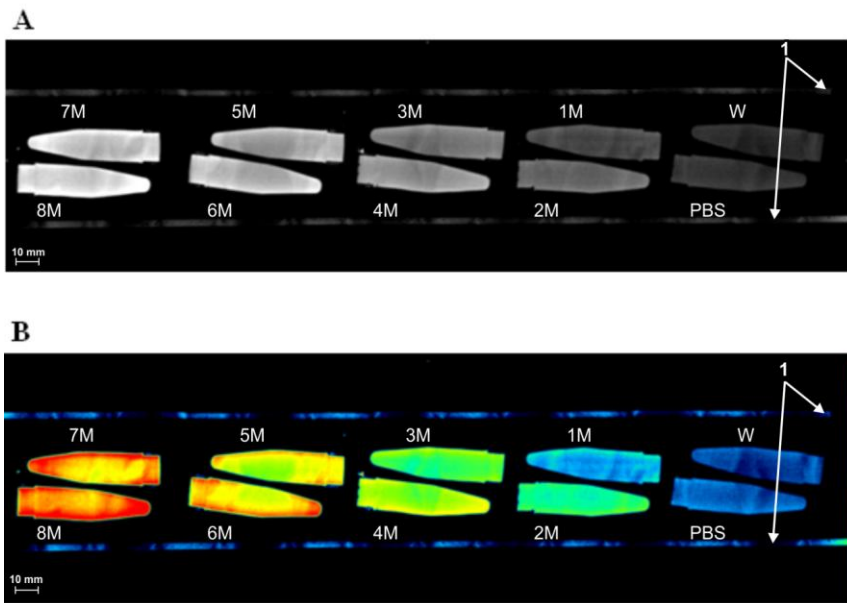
CT image of 10 Eppendorf tubes with different solutions of Me₂SO in PBS, at 20 °C. Top image (A) uses the gray scale and bottom image (B) the cold scale. In both scales, bottom row, from right to left, correspond to: 0M (PBS), 2M, 4M, 6M and 8M Me₂SO, and top row, from right to left: water, 1M, 3M, 5M and 7M Me₂SO
